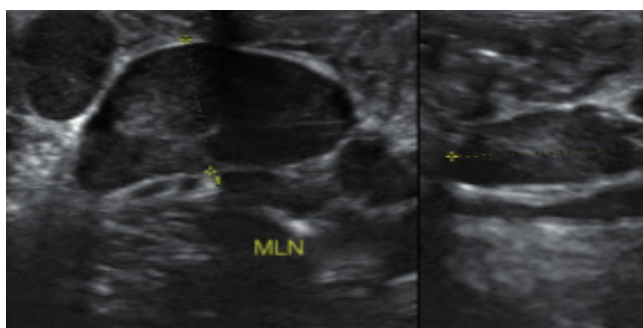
Mesenteric lymph node measurement in short axis in abdominal sonographic evaluation.
